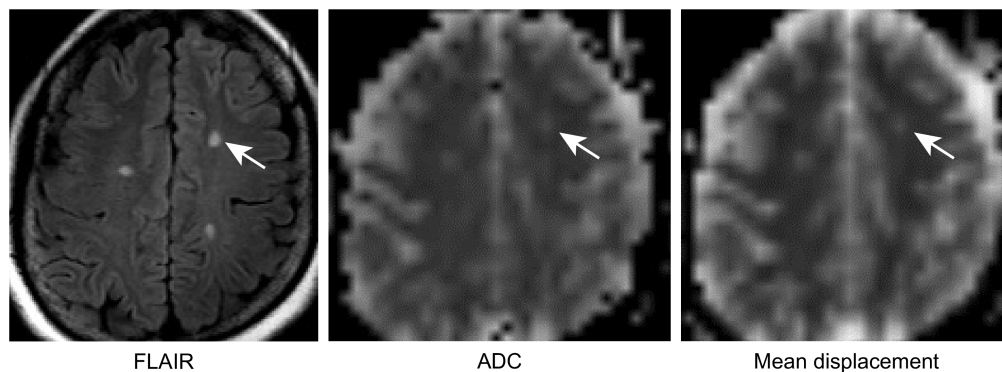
Images from a patient with MS. FLAIR image shows the demyelinated lesions as abnormal hyperintensity spots. The corresponding map of ADC from a DTI analysis and a mean displacement map from a QSI analysis show the lesions as abnormally high values compared with surrounding white matter. ADC, apparent diffusion coefficient; DTI, diffusion tensor imaging; FLAIR, fluid-attenuated inversion recovery; QSI, q-space imaging.
